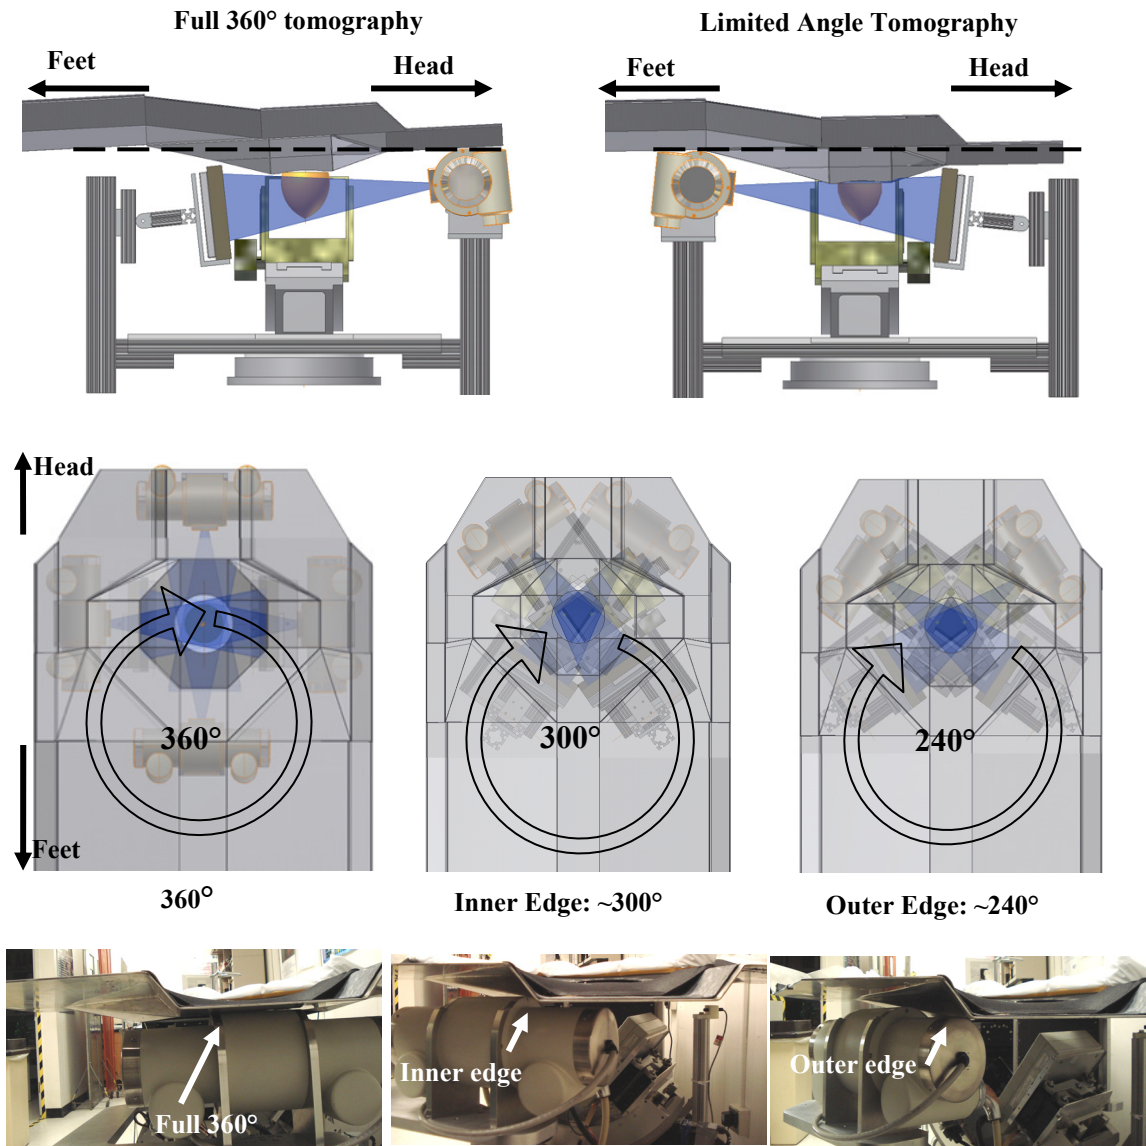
CAD images from a side perspective of the integrated SPECT-CT system performing (top, left) a full 360° azimuthal rotation with the bed tilted and raised, and (top, right) limited angle trajectory with the bed lowered and flattened. Note the increase in imaged breast volume when the bed is lowered/system is raised. (Middle, left) Top-down view of the CT system rotating the full 360° underneath the patient bed, and (middle, right) top-down views of the SPECT-CT system performing limited angle tomography up to the inner (300°) and outer (240°) edges of the tube. (Bottom row) Photographs of the CT tube (left) passing unrestricted under the head section of the bed, (middle) impacting the bed at the inner edge for 300° rotation and (right) impacting the bed at the outer edge of the tube for 240° rotation.
